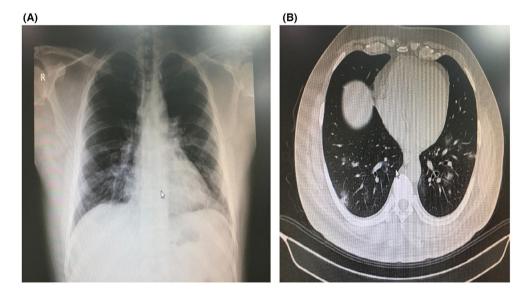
Chest radiograph of Pakistanis patient. A, Chest X-ray of Pakistanis patient showed right basal fine reticular changes; while B, CT scan chest showed bilateral lower lobes few small nodules GGO, minimal bronchiolar dilatation noted on the left side
